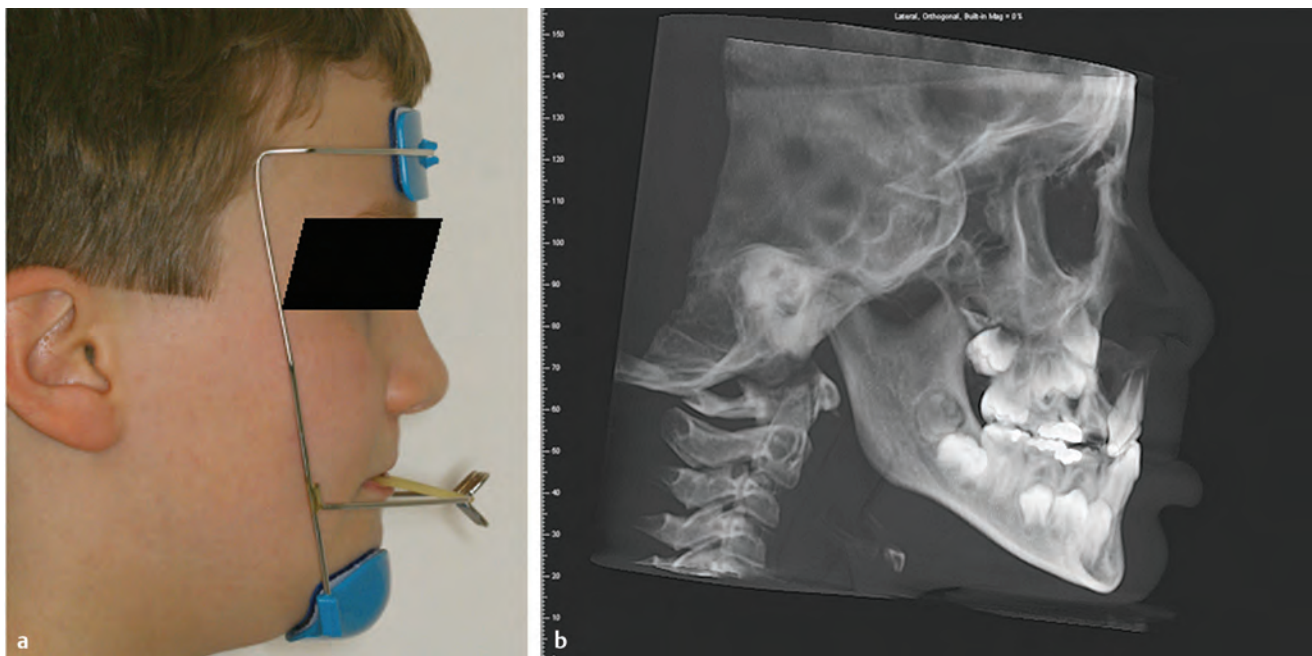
(a) Reverse-pull headgear. (b) Lateral cephalometric radiograph—bilateral complete cleft lip and palate before premaxillary osteotomy.
